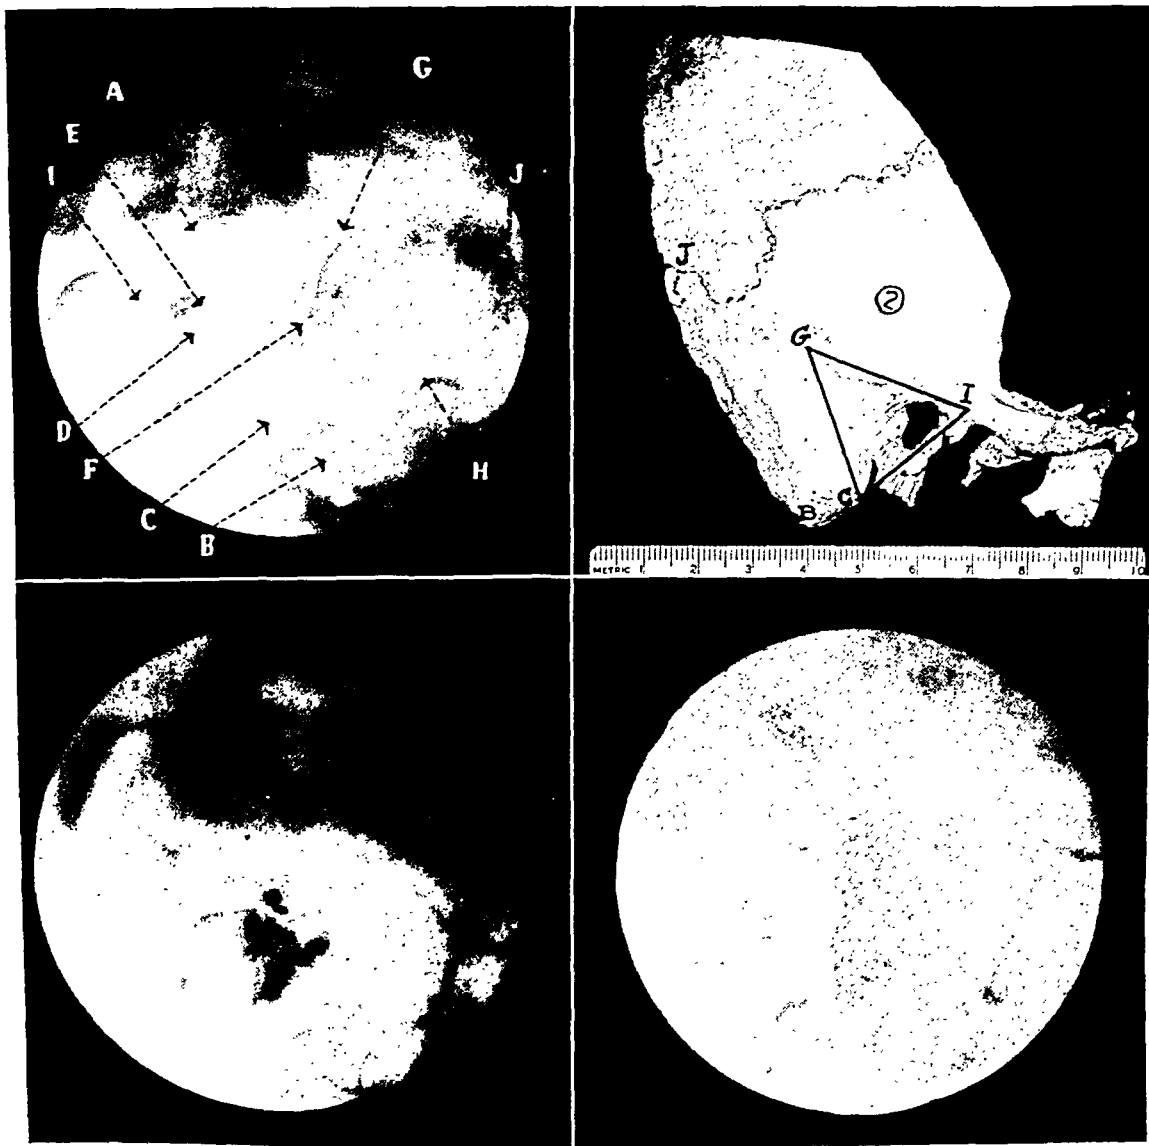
(*upper left*). The peri-antral triangle (radiograph of an undeveloped mastoid). *A*, arcuate eminence or tegmen line; *B*, center of mastoid tip; *C*, tympano-mastoid fissure (lower angle of triangle); *D*, floor of external meatus; *E*, posterior wall of external meatus; *F*, sinus plate (anterior lip of groove); *G*, parietal notch; *H*, emissary vein at posterior border of mastoid; *I*, post-glenoid process, and *J*, asterion.
